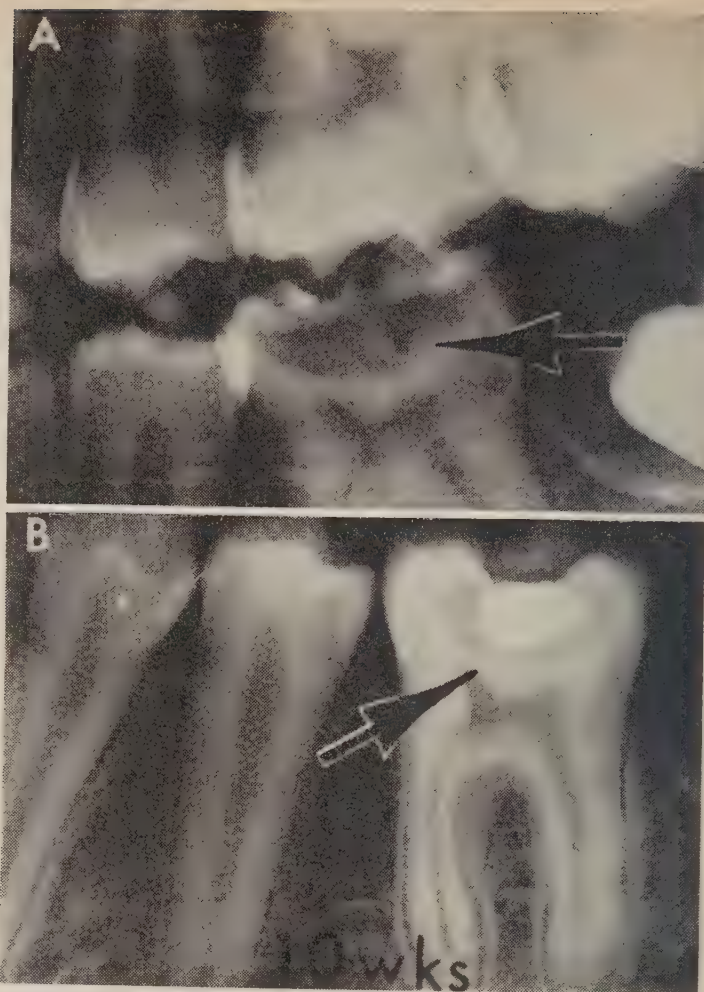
A, radiograph showing a deep carious lesion in the mandibular first molar of a 14 year old patient. B, the same tooth 10 weeks after indirect pulp capping. Arrow points to a thin semilunar band of radiopaque remineralized dentine.
